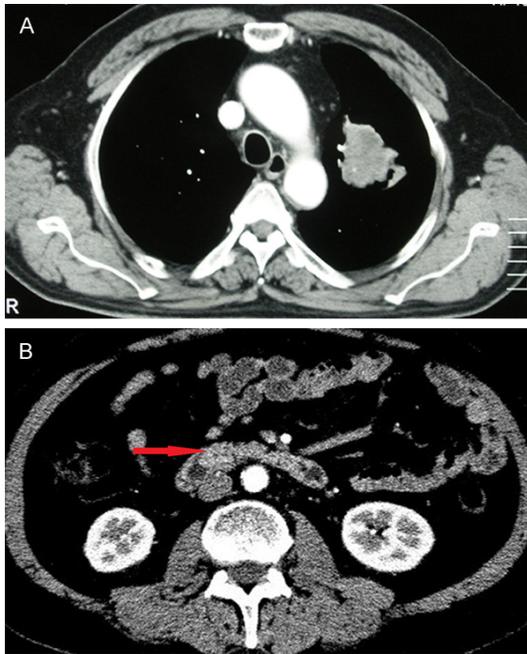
Chest and abdominal CT scan showing primary pulmonary adenocarcinoma and periampullary metastasis. A. Contrast-enhanced chest CT scan revealed a solitary round-like mass measuring 3.7×2.8 cm in the upper lobe of the left lung. B. Abdominal CT scan showed a lesion with 1 cm in diameter in Vater ampullary (red arrow).
